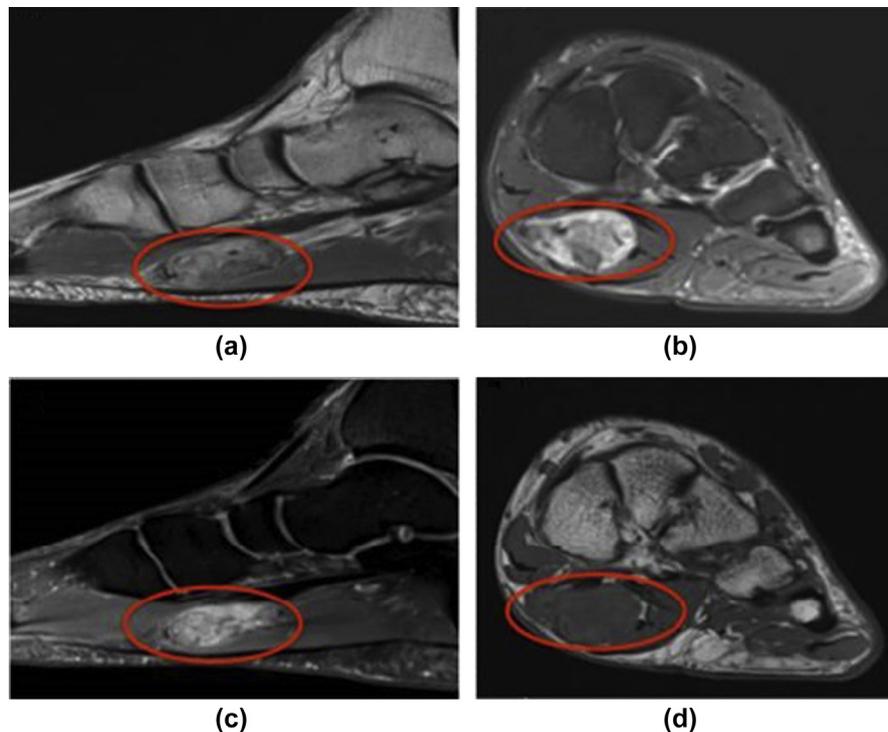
(a) T1 Sagittal, (b) STIR coronal, (c) STIR sagittal, (d) T1 coronal MRI images shows a round, encapsulated mass isointense–increased signal intensity to the surrounding muscles, located at the knot of Henry. FS images show a high intensity peripheral rim lesion with central intermediate signal intensity. This is typical of a “target sign,” seen in peripheral nerve sheath tumours such as schwannoma or neurofibroma.
